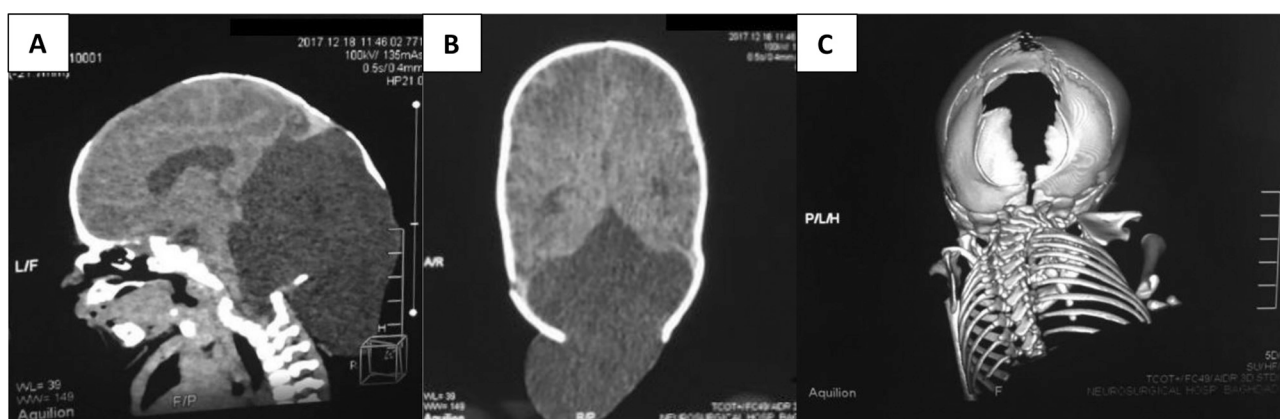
(A, B) sagittal and axial CT scan showing hypoplasia of the vermis with enlarged posterior fossa as cystic dilation of both ventricles with herniation through a bone defect (C) sagittal suture diastasis.
